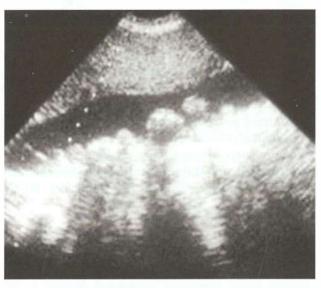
Ultrasonography showing posterior acoustic shadows
